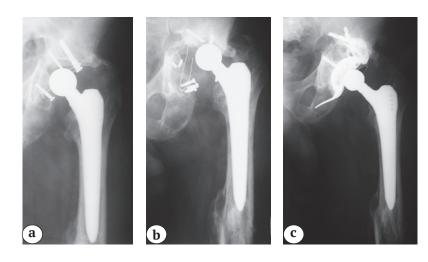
X-rays of male patient 26 y.o.: a — total hip arthroplasty RM-CBH due to posttraumatic coxarthrosis with nonunion of the pelvic ring rupture; b — aseptic instability and failure of cup in 8 years; c — revision arthroplasty with bone grafting
